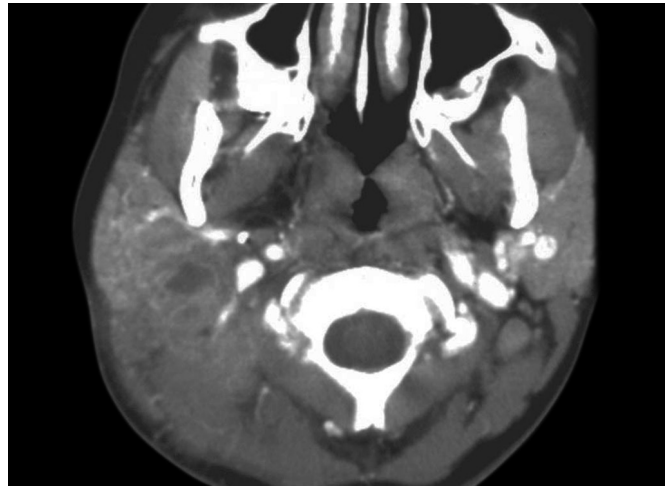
Bezold's abscess. Contrast enhanced axial CT reveals a medially placed rim-enhancing small abscess just medial and below the mastoid tip in this case.
